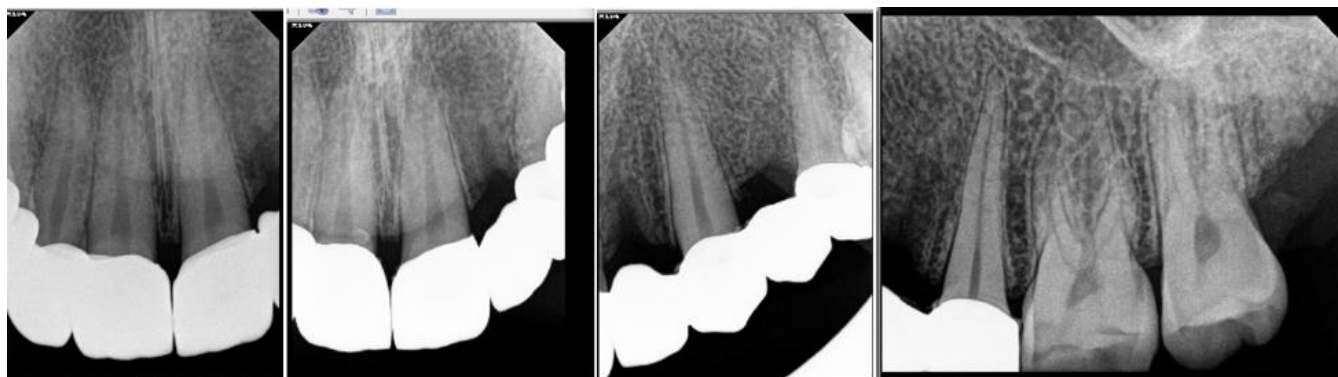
different postoperative periapical x-rays after cementation of zirconia restorations
